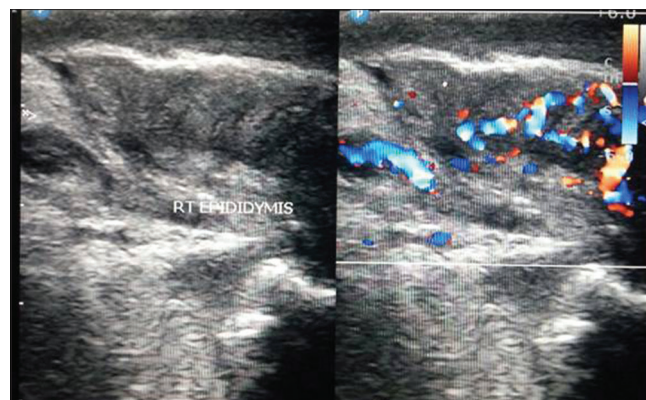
Grey scale and color Doppler image
